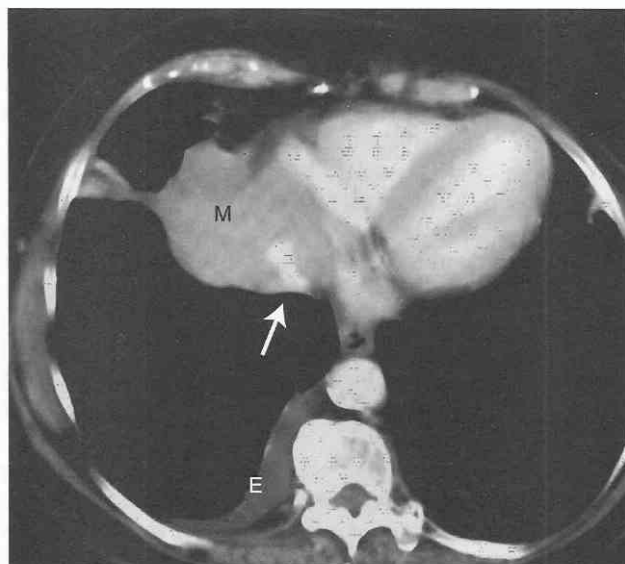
Pericardial mesothelioma. Axial contrast-enhanced CT scan shows a large mass (M) arising from the right pericardium, invading the right atrium, and encasing the inferior vena cava (arrow). The patient was initially seen at an outside hospital, where the mass was thought to be arising from the lung. Bronchoscopic findings were negative. The patient was referred for biopsy. E, effusion.
